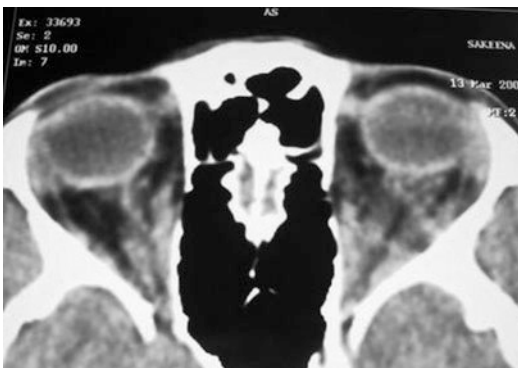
Orbital fat infiltration on CT scan
